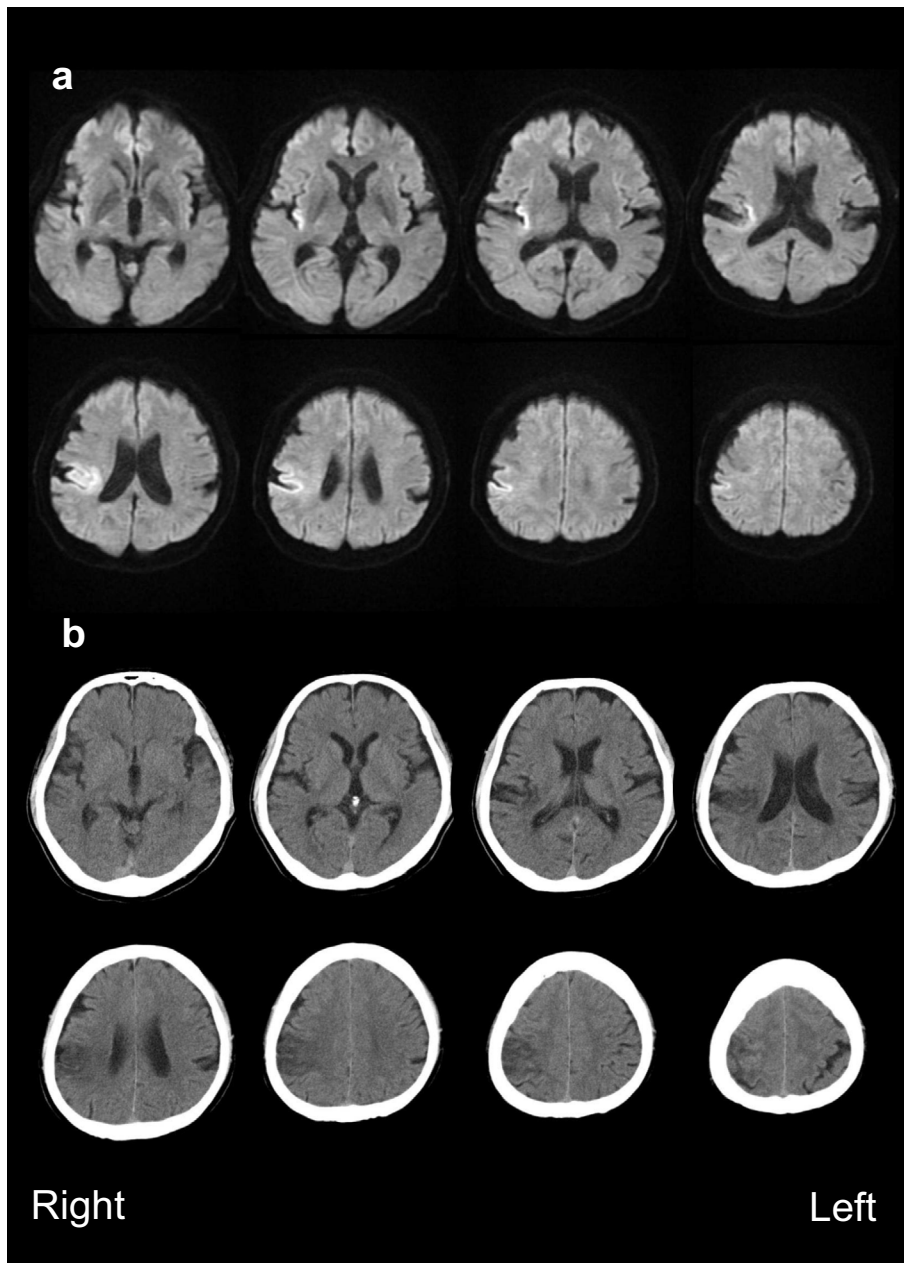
(a) Diffusion-weighted magnetic resonance images of the head. High-intensity areas are localized to the upper portion of the right posterior insula, postcentral gyrus, and supramarginal gyrus, as well as the white matter under these structures. (b) Computed tomography images of the head. Low-density areas are localized to the upper portion of the right posterior insula, postcentral gyrus, supramarginal gyrus, and anterior upper portion of the angular gyrus, as well as the white matter under these structures.
